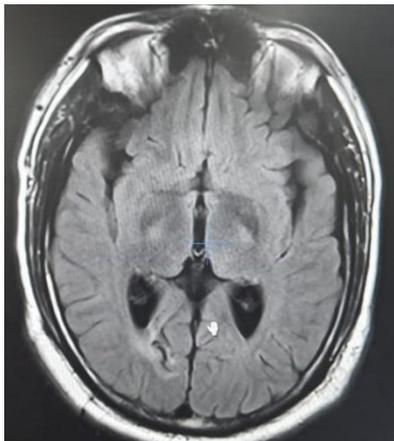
T2W MRI showing gliotic lesion in the right occipital area near optic radiation
